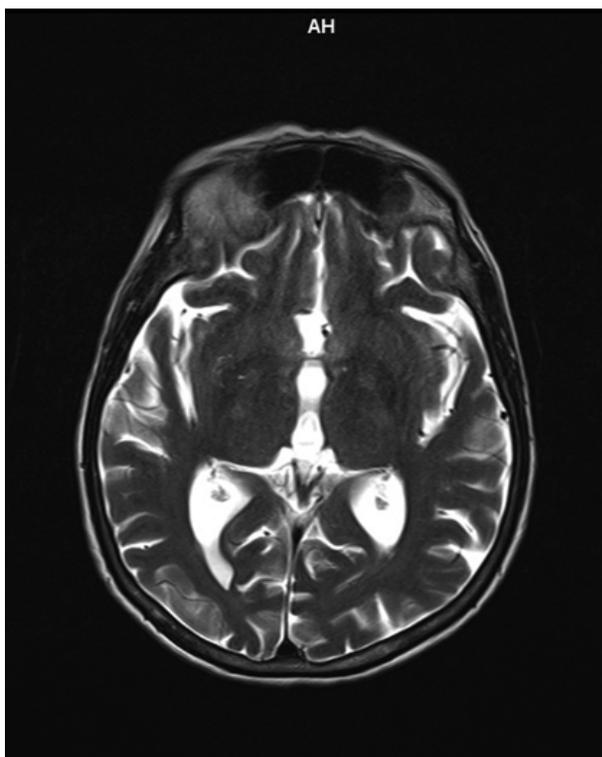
No corresponding signal changes are evident in the globus pallidi in the MRI T2-weighted image.
